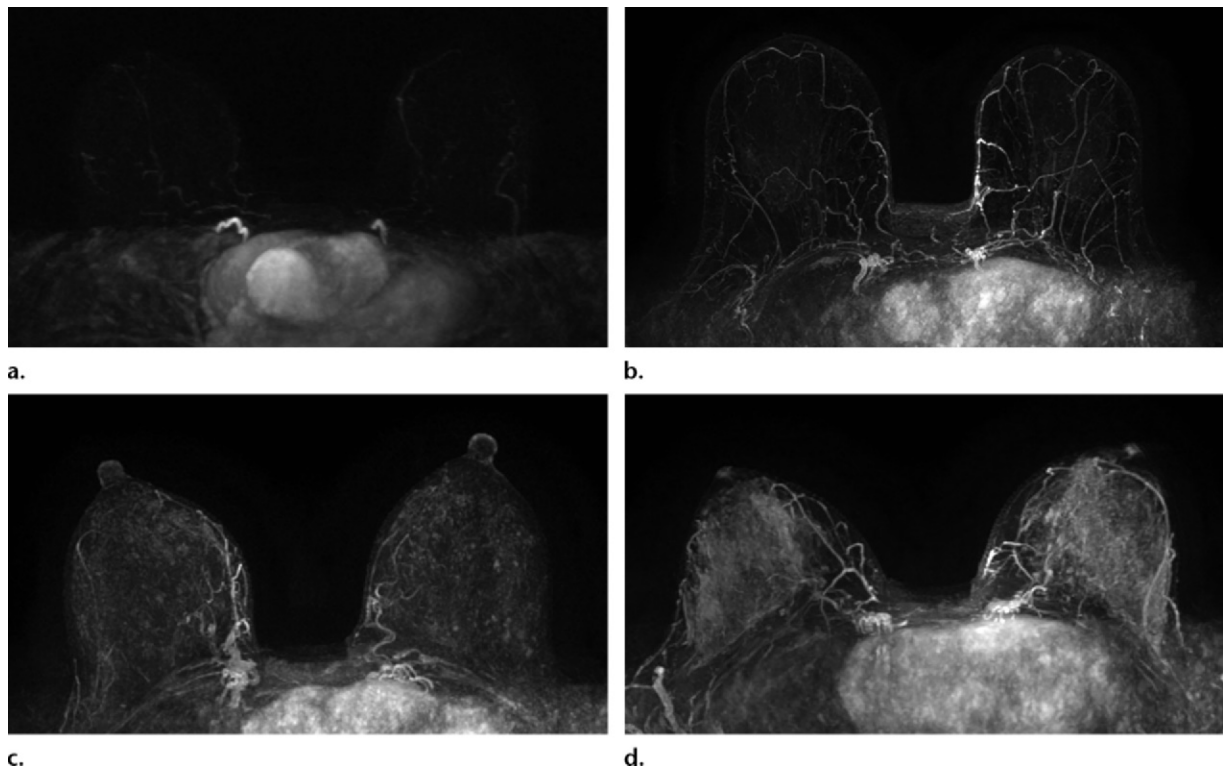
Background parenchymal enhancement. This descriptor is a visual estimate of the amount of enhancement. Axial contrast-enhanced maximum intensity projection MR images show minimal (a), mild (b), moderate (c), and marked (d) enhancement.
